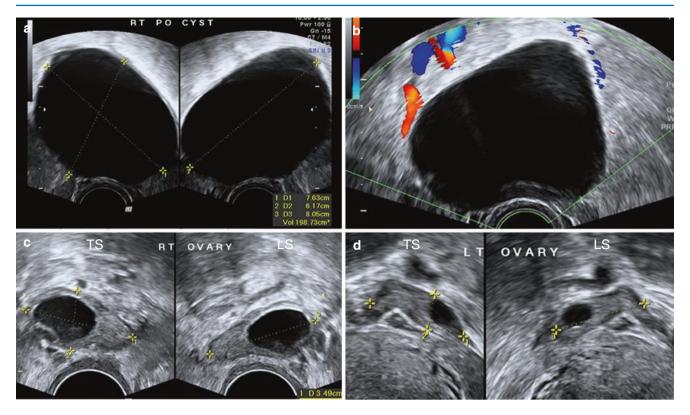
Case of PO cyst with typical ultrasound findings. (a) Anechoic, unilocular, thin-walled cyst (198 cc). (b) Cyst wall shows low vascularity. (c, d) Normal right and left ovaries are seen separate from the cyst
